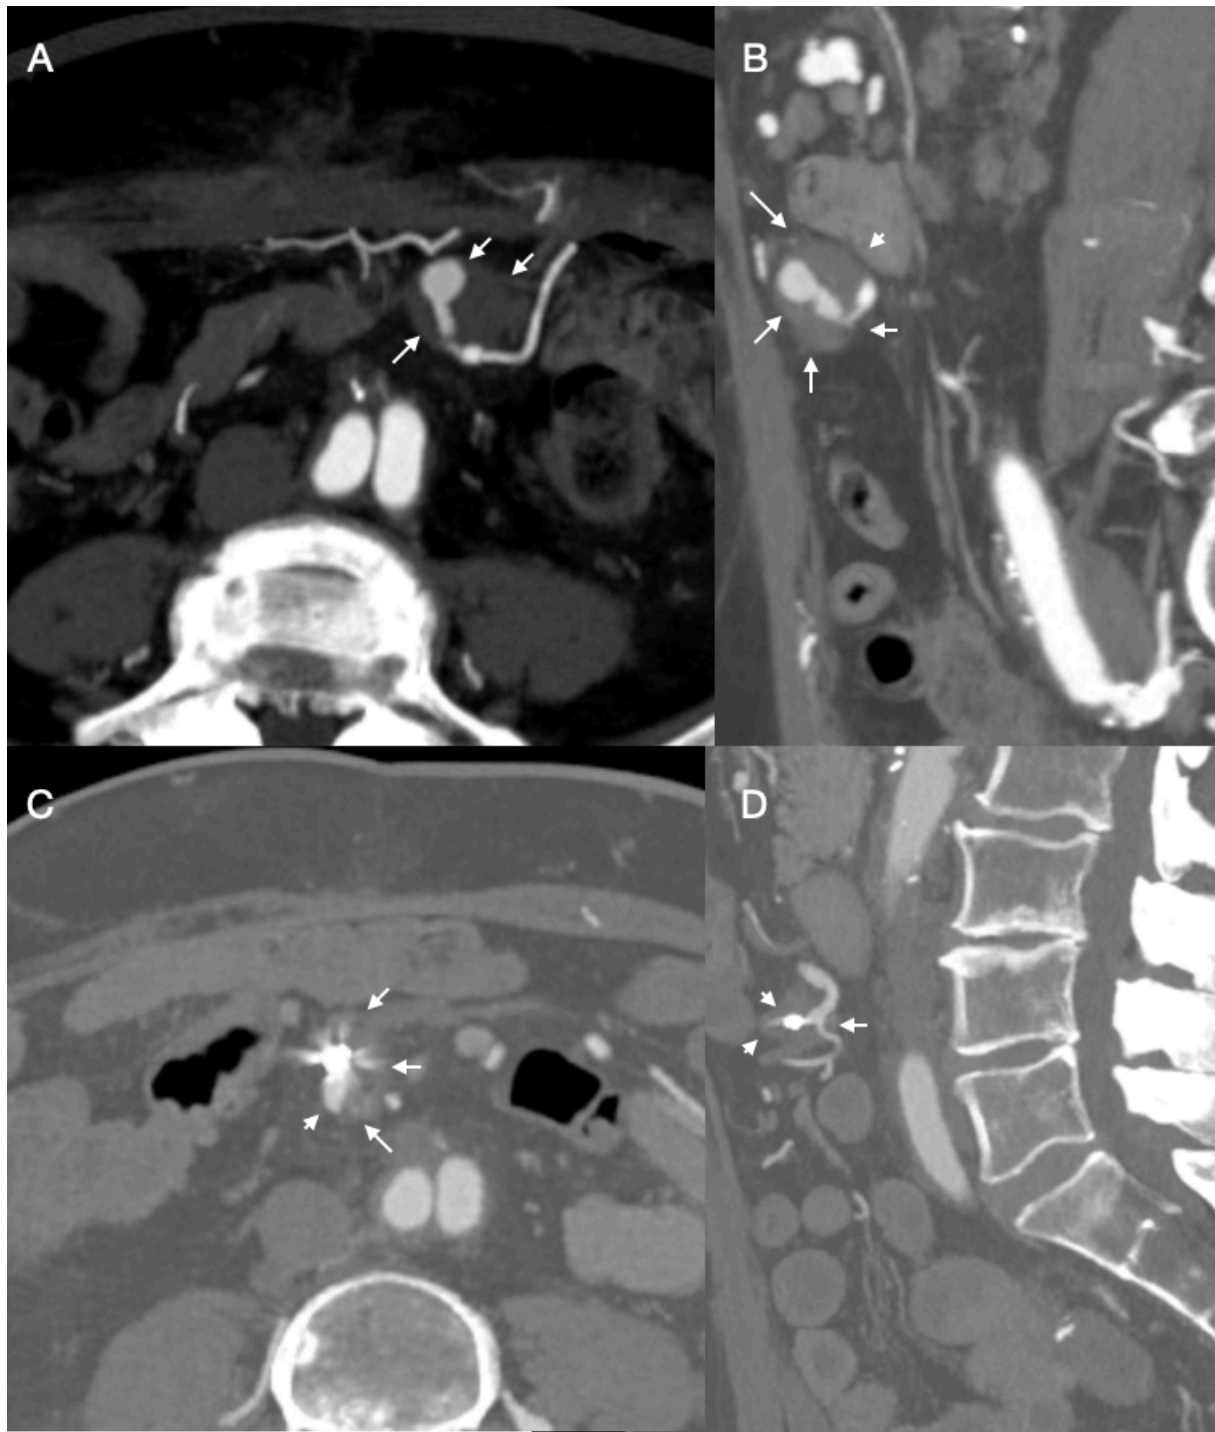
A) and B) CT axial & sagittal showing a big aneurysm spurium of a branch of colic medial artery with partial thrombosis - Arrows. C) and D) Complete thrombosis of shrinking aneurysm after coiling - Arrows.
